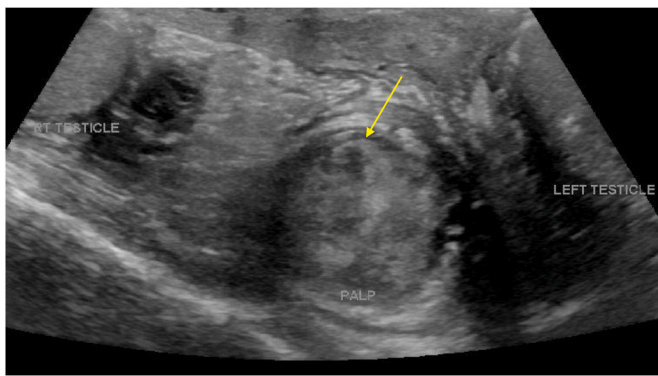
Scrotal Ultrasound
